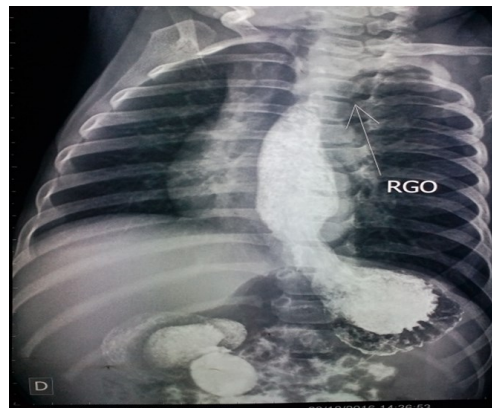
The first contrast gastrointestinal radiographic studies interpreted as a massive gastroesophageal reflux and after re-examination a dilated antrum was noted and a non-specific obstacle at the level of the pylorus was suspected.
